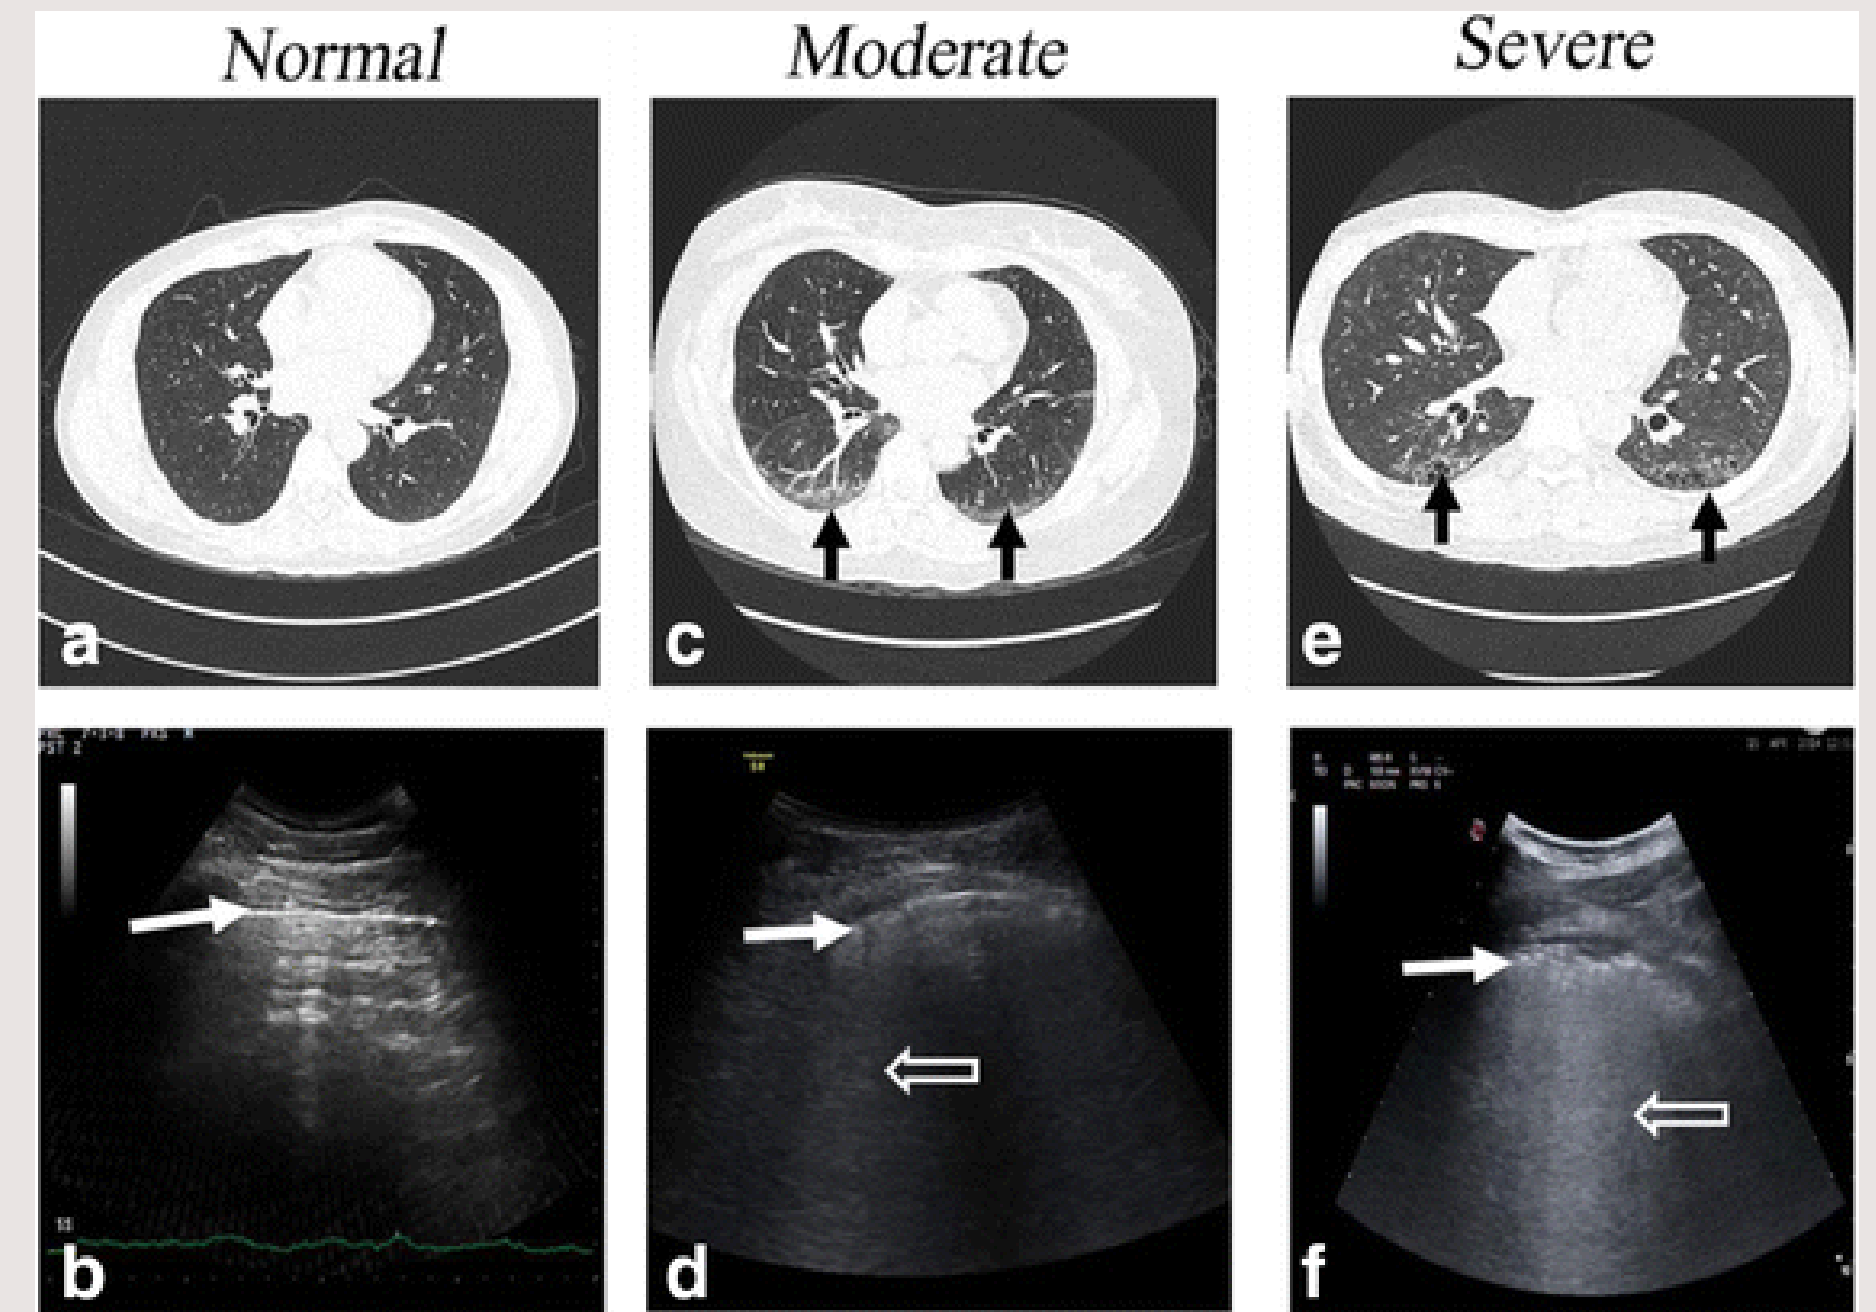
Comparison of ultrasound B-lines and high resolution computed tomography³⁹
